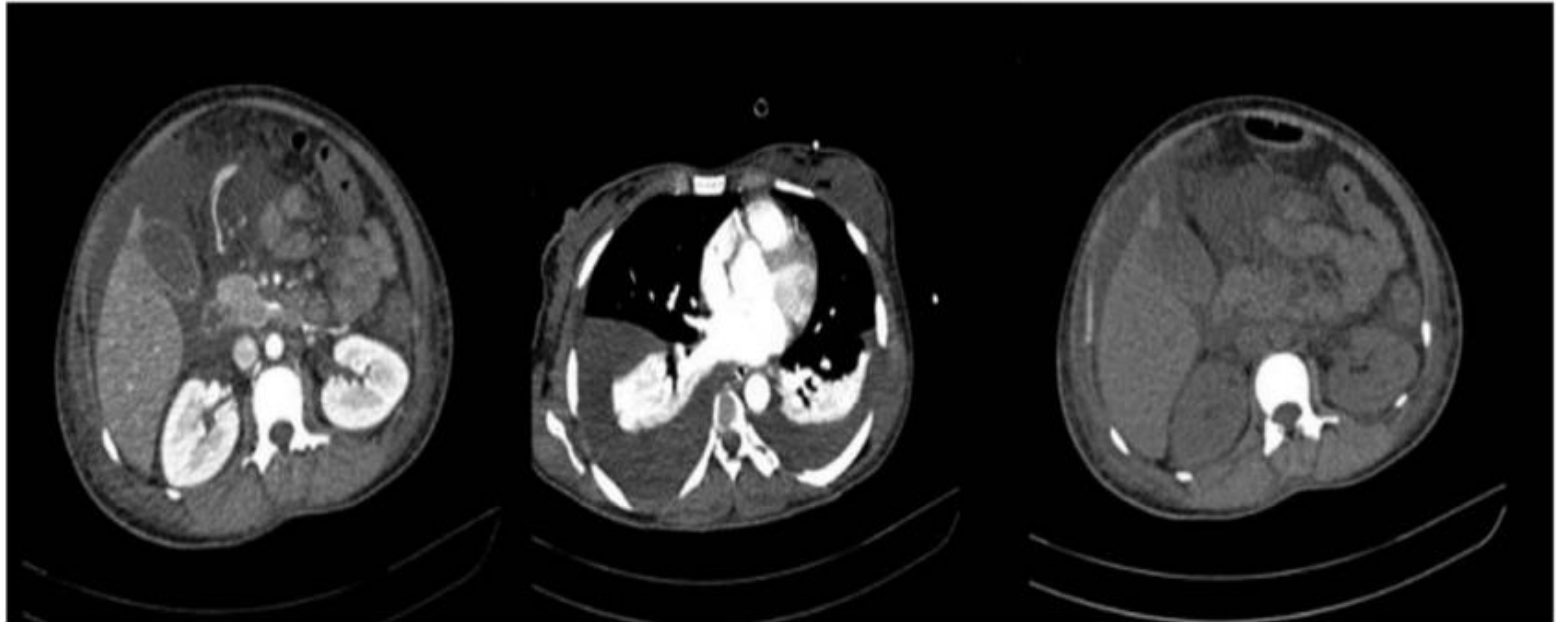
Computed tomography scan of whole abdomen: Gross ascites with large amount of bilateral pleural effusion with bilateral lower lobe atelectasis.
